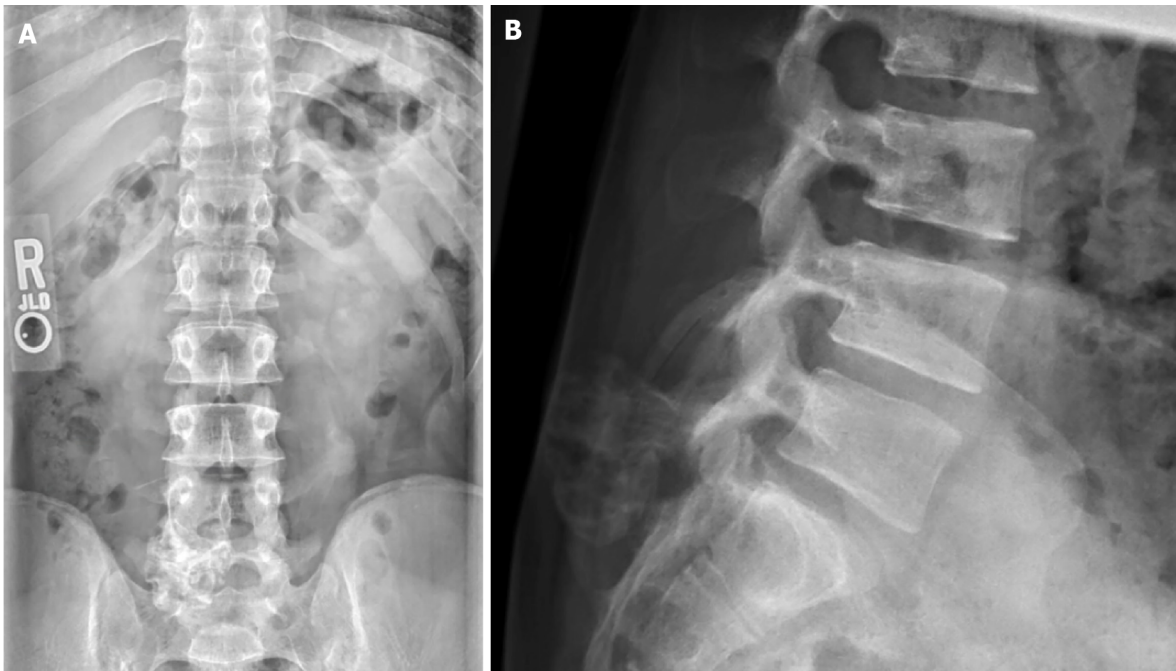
Anterior to posterior and lateral radiographs demonstrating calcified, pedunculated mass protruding from the posterior elements of the L5-S1 vertebral interval. A: Anterior to posterior radiograph; B: Lateral radiograph.
